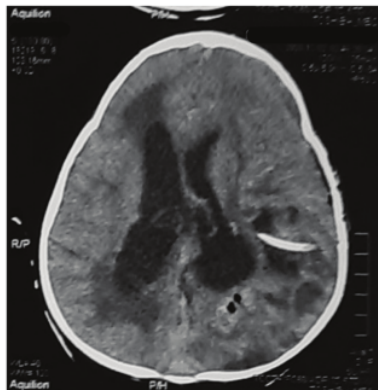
The head's postoperative computed tomography scan showed a massive reduction in abscess size, with intracapsular drainage inserted into the abscess capsule. The midline shift is no longer visible, and the left lateral ventricle was released from the pressure.
